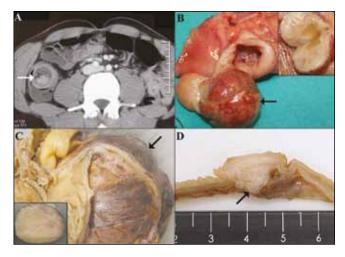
CT scan demonstrating a sausage-shaped mass (arrow) (A). Polypoid IMFT (arrow) as lead point of intussusception (B) with myxoid degeneration (inset). Ileo-caecal mass (arrow) (C) with a solid, whorled appearance (inset). Firm stricturing mass (arrow) with trans-mural involvement (D).
